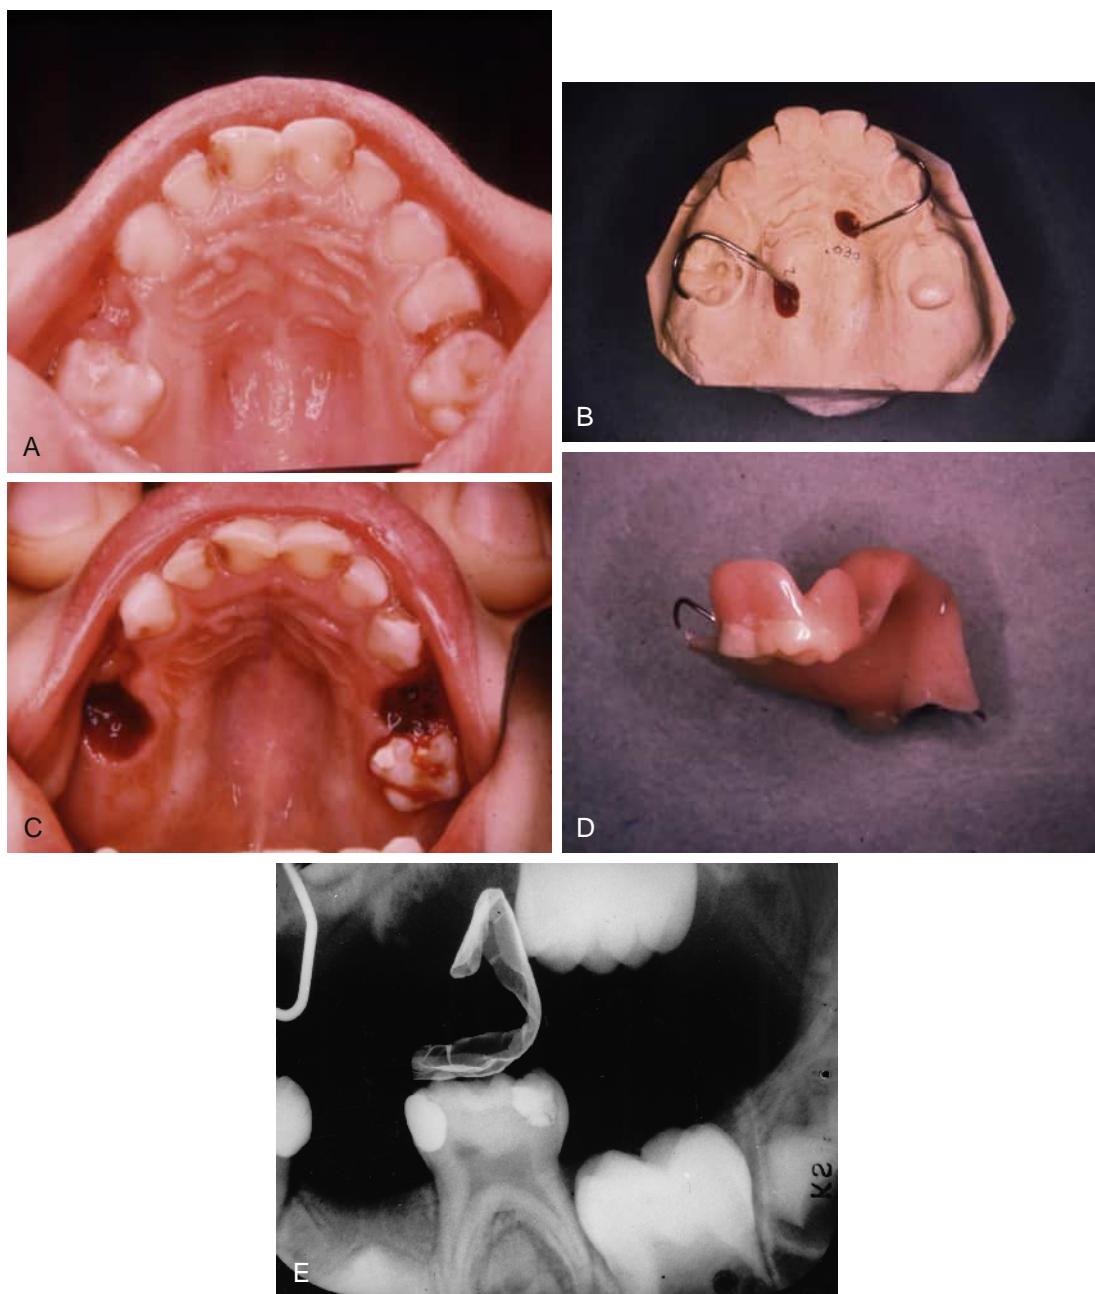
(A) Clinical and radiographic examination revealed the need for extraction of both maxillary first primary molars and the left second primary molar at 6 years of age. (B) The teeth indicated for extraction are cut away from the stone model, and a depression is made in the second molar area for an acrylic distal shoe-type extension. (C) The primary teeth have been extracted in preparation for the placement of the partial denture. (D) The acrylic distal shoe extension. (E) Lead foil has been placed over the tissue extension to determine, with the aid of a radiograph, whether the acrylic is positioned properly to guide the eruption of the first permanent molar. (Courtesy Dr. Paul E. Starkey.)
